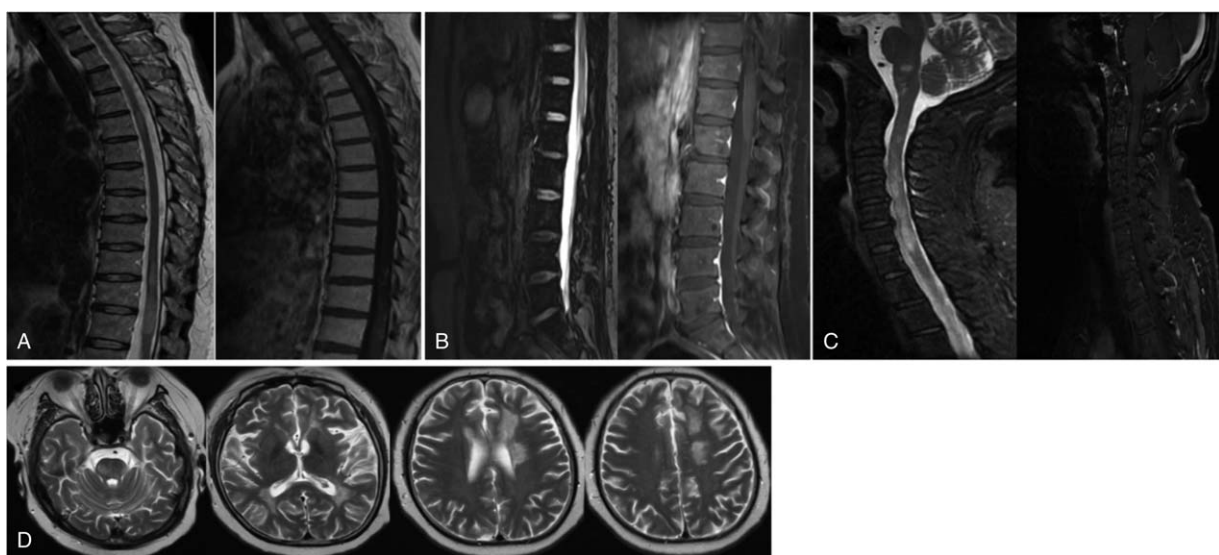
Thoracic MRI showed an extension of T2 lesions in T1, T3, T5, T10–12 with gadolinium (Gd) enhancement (A). Lumbar MRI showed long T1 long T2 signal in spinal conus with Gd enhancement (B). MR FLAIR imaging demonstrated multiple hyperintense lesions. Several lesions were found to be Gd enhancing on T1 (C). Brain MRI showed multiple hyperintense T2 lesions on the brain stem, bilateral ventricles, the left corona radiata, the centrum semiovale, and the white matter bilateral frontal with non-contrast enhancement (D).
